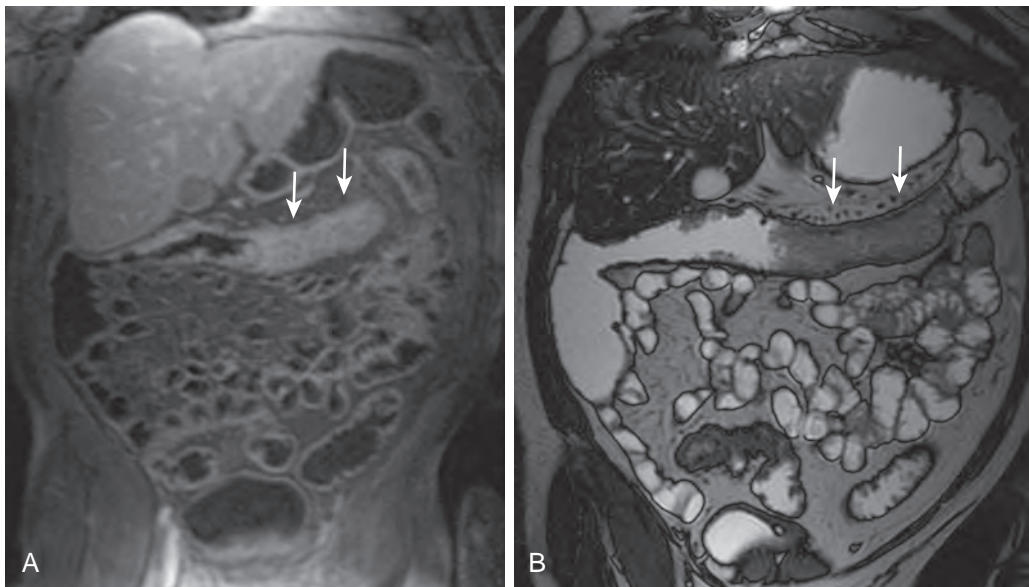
Crohn's disease with MRC. This patient with Crohn's disease showed increased contrast enhancement of the transverse colon (arrows) on the T1-weighted image (A) and bowel wall thickening on the true FISP image (B).
